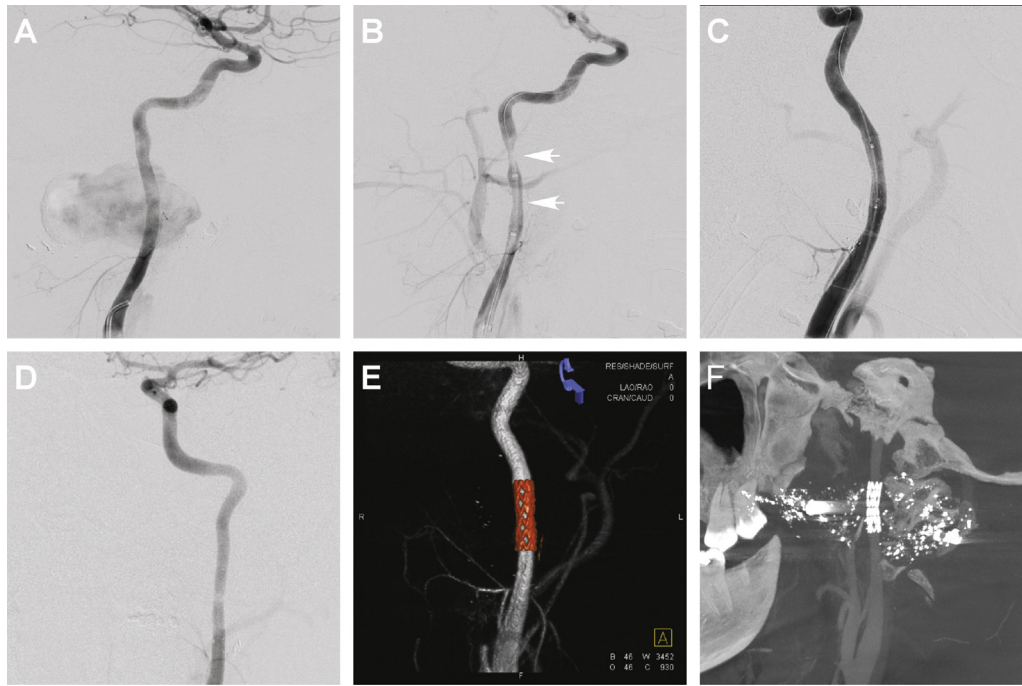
Treatment and follow-up: (A) digital subtraction angiography, left ICA lateral projection demonstrating the large low-flow pseudoaneurysm and a stenotic region just distal to the pseudoaneurysm. (B) Left ICA lateral projection after stent graft deployment demonstrates no filling of the pseudoaneurysm but an area of mid-stent stenosis and vasospasm distal to the stent (white arrows). (C) Left ICA lateral projection after angioplasty. (D–F) Follow-up angiography 10 weeks later. (D) Left ICA AP projection demonstrating no residual pseudoaneurysm filling or vessel stenosis. (E) Three dimensional rotational angiography dual-density virtual projection and (F) maximum intensity projection, sagittal reconstruction cone-beam CTA demonstrating the stent graft without evidence of stenosis or malapposition.
